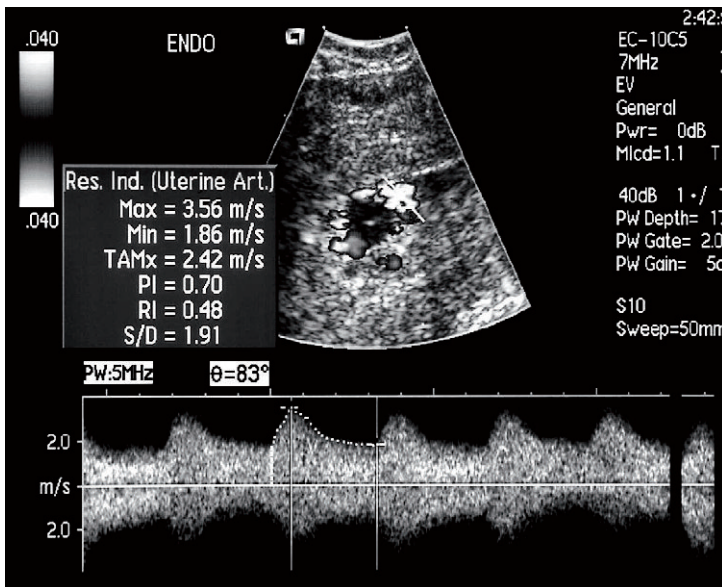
Spectral Doppler in retained products of conception. The resistance index of 0.48 implies residual trophoblast.
